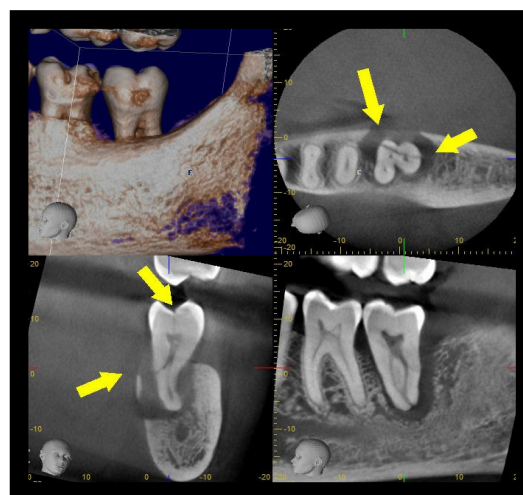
CBCT depicting vertical root fracture
